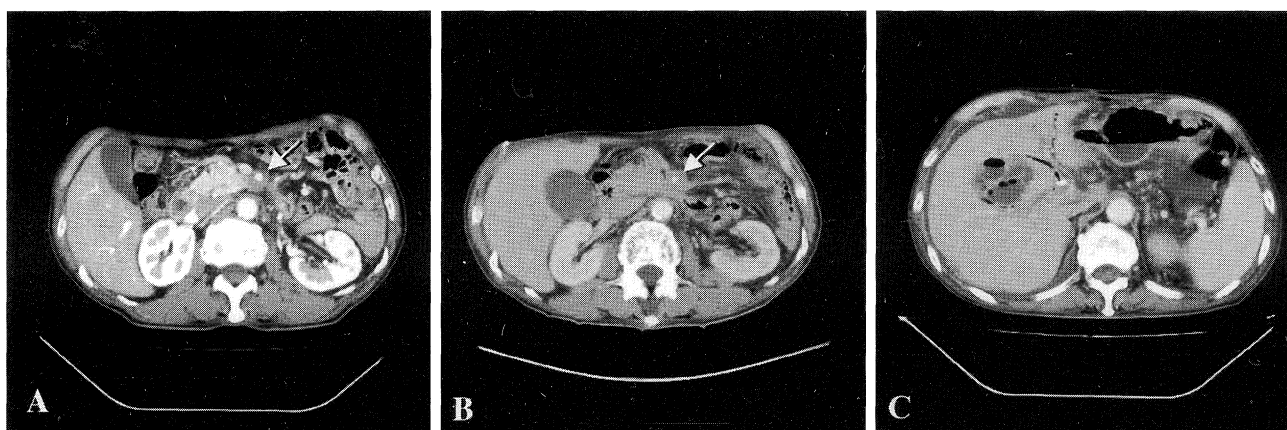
CT scan of the abdomen with intravenous contrast. A. CT scan prior to treatment demonstrate periarterial (superior mesenteric arteries) soft tissue (arrow). B. CT scan performed four months after treatment shows no reduction in the size of the periarterial soft tissue (arrow). C. CT scan shows a low-density lesion of the liver which is compatible with the abscess.
